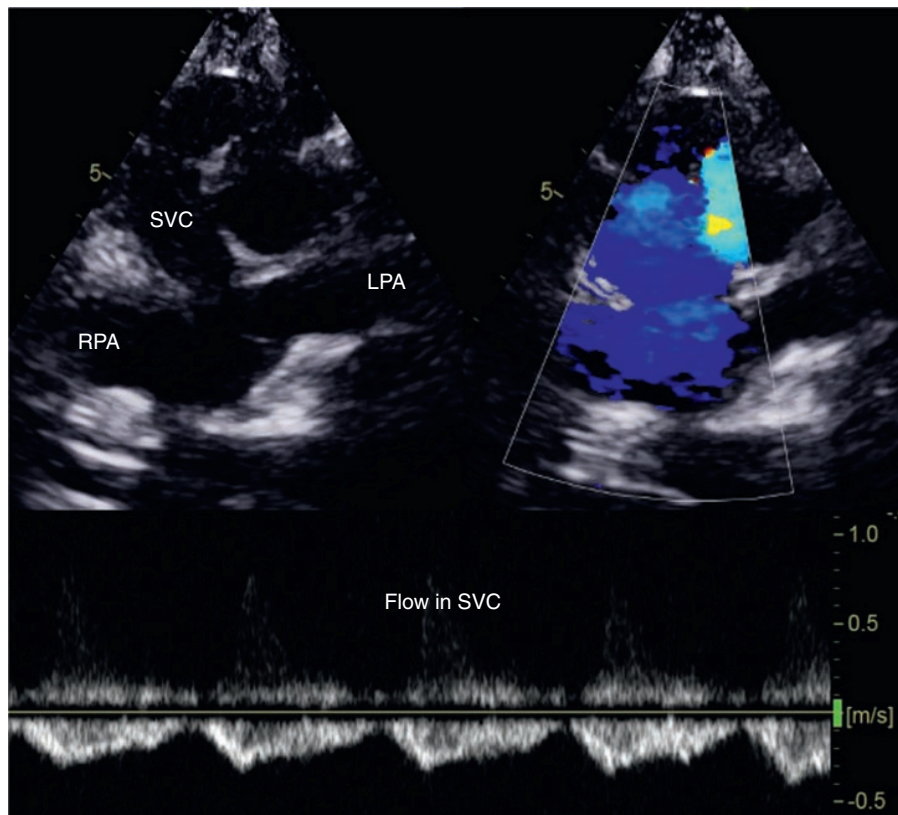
This suprasternal view demonstrates the connection between the superior vena cava (SVC) and the left and right pulmonary arteries (LPA and RPA). The flow is laminar into good-sized pulmonary arteries with low-velocity flow as shown on spectral Doppler.
